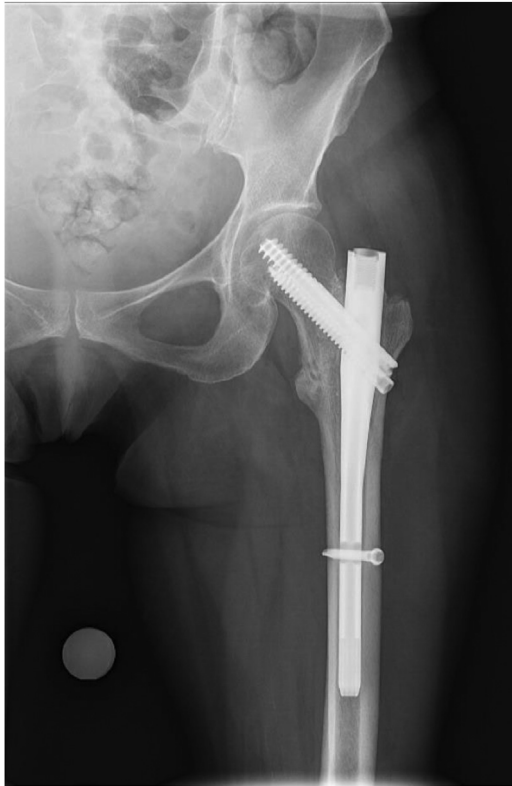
AP Radiograph of left femur with Intertan (Smith & Nephew) nail. This nail can be distinguished from its Stryker, Depuy-Synthes, and Zimmer counterparts by the presence of both a lag screw and compression screw, whereas most other cephalomedullary nails have a single lag screw or helical blade option.
